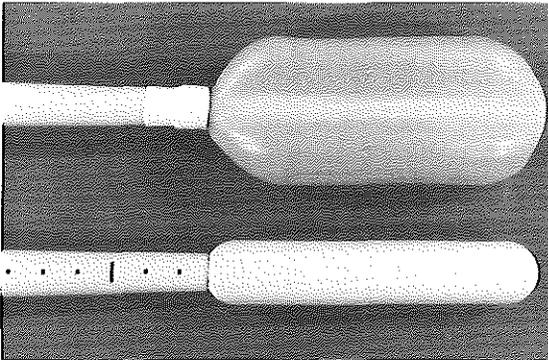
Endoluminal coil for (upper) endorectal and (lower) endoanal MRI.
